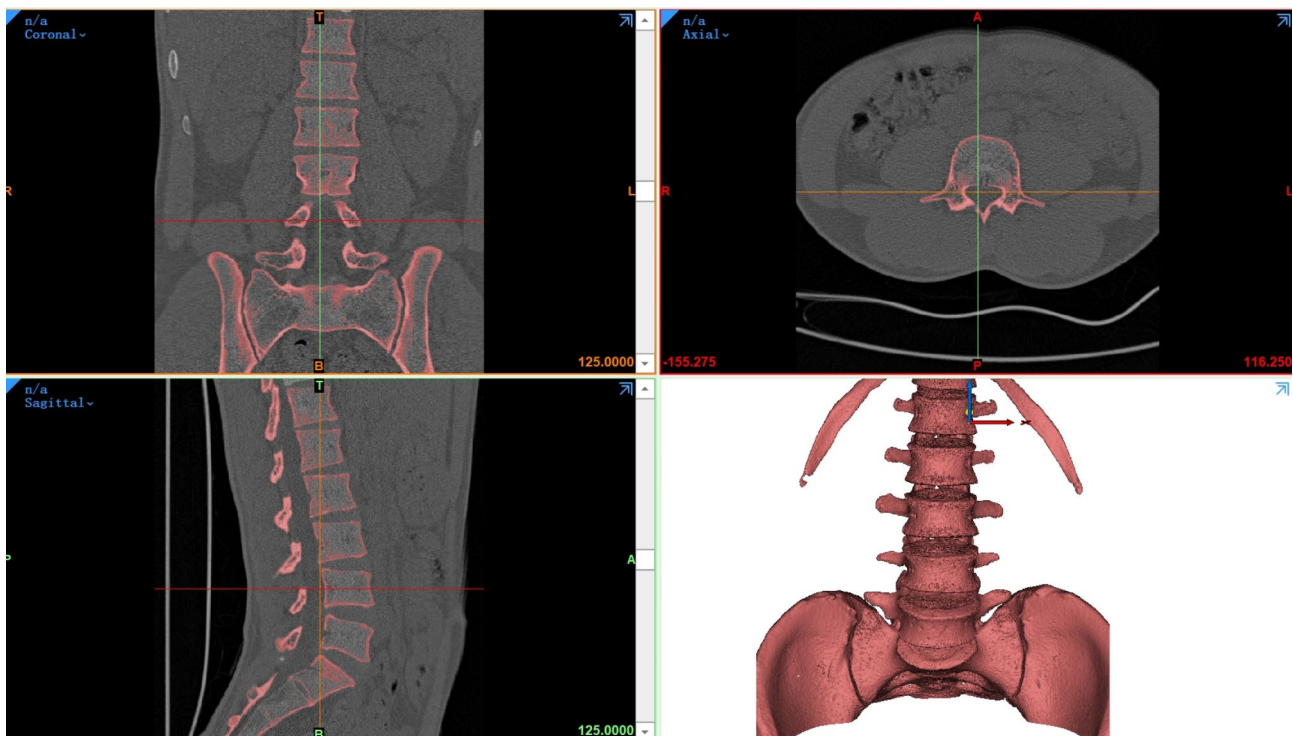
The volunteer lumbar spine CT image
